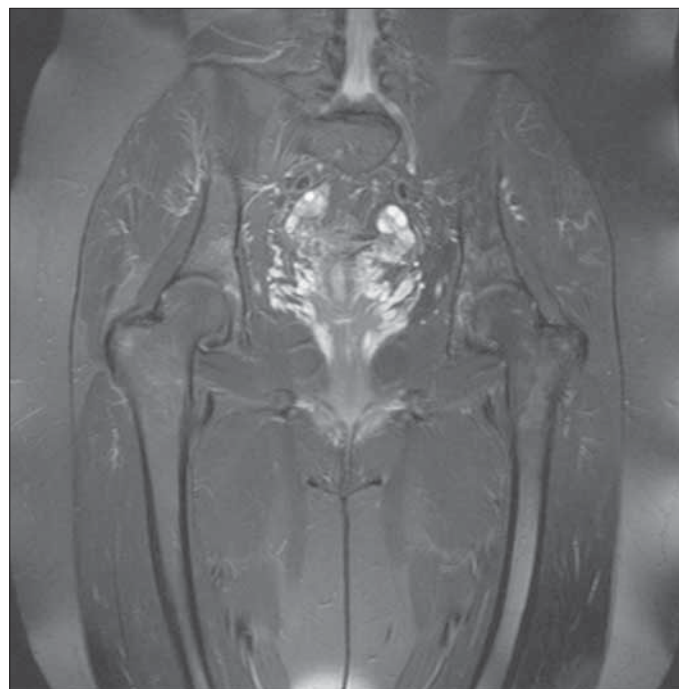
Fat suppressed T2 weighted sequences of the control MRI postpartum demonstrated normalization of bone marrow edema
